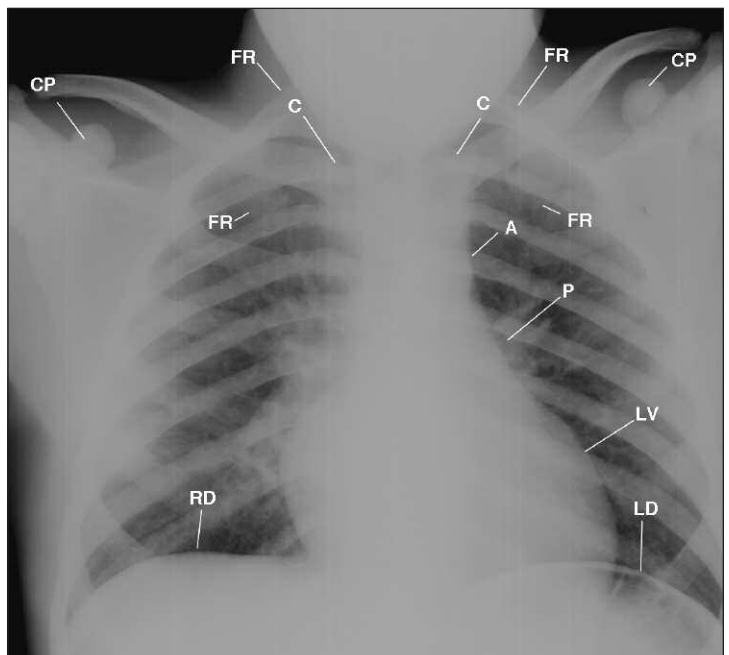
This posteroanterior (PA) chest radiograph displays hunched-up, rounded shoulders (signifying weakness due to anemia); forward shift of the cervicothoracic spine; sloping of the dense posterior ribs; absence of the spleen, and an enlarged heart. A = aorta; C = clavicle; CP = coracoid process; FR = first rib; LD = left hemidiaphragm; LV = left ventricle; P = pulmonary artery; RD = right hemidiaphragm.
